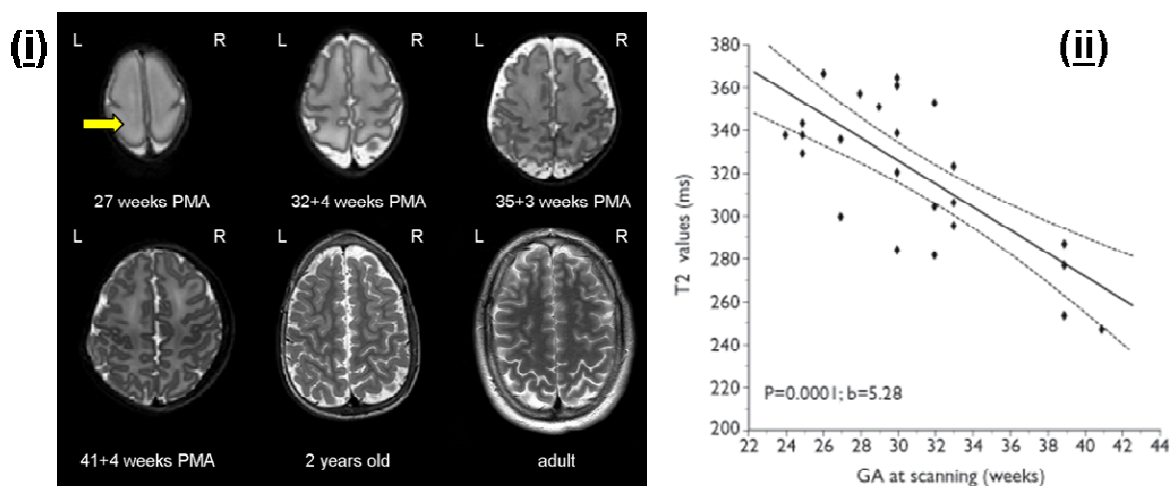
(i): Marked maturational changes in the appearances of the brain can be seen on T2-weighted MR imaging. At 27 weeks PMA, the brain is relatively smooth with only the central sulcus visible bilaterally. The white matter is of high signal, and concentric “bands” representing the laminar structure of the developing cortex are still visible (yellow arrow). Sulcation and gyrification can be seen to progress through the third trimester, with a progressive decrease in the white matter signal. The appearance of the 2 year old brain is far more similar to that of the mature adult brain on T2-weighted MR imaging, with a rich and complex pattern of cortical folding and low signal in the white matter (*Images not to scale*). (ii): The T2 value of the white matter in the centrum semi-ovale shows a linear decrease with increasing PMA (figure (ii) reproduced from Counsell et al. 2003).
